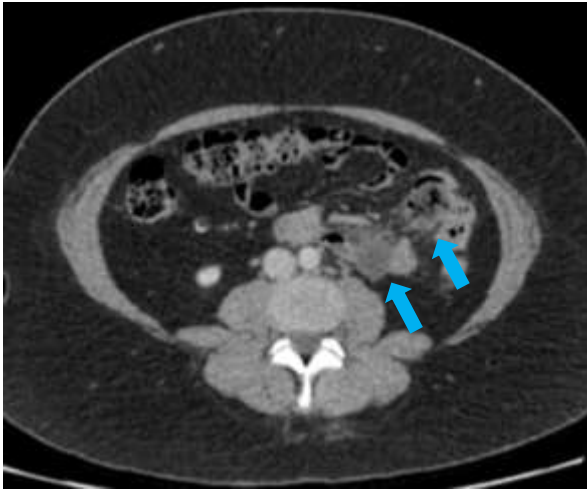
CT axial imaging showing simple jejunal diverticulitis from 5 years prior (blue arrows).
